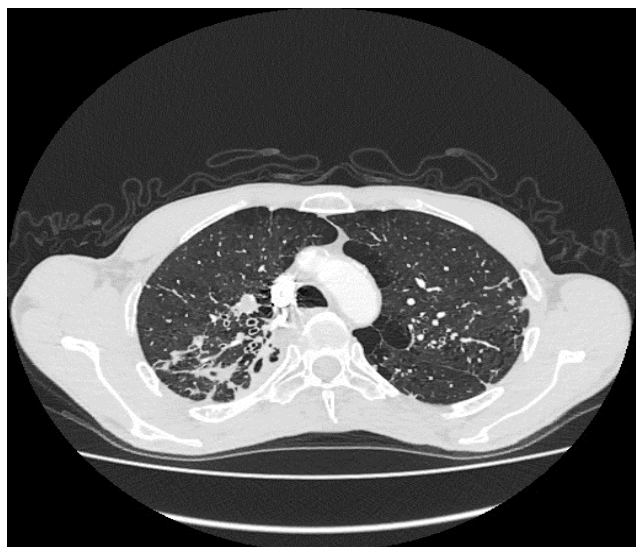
Patient 2 (chest CT scan.)
